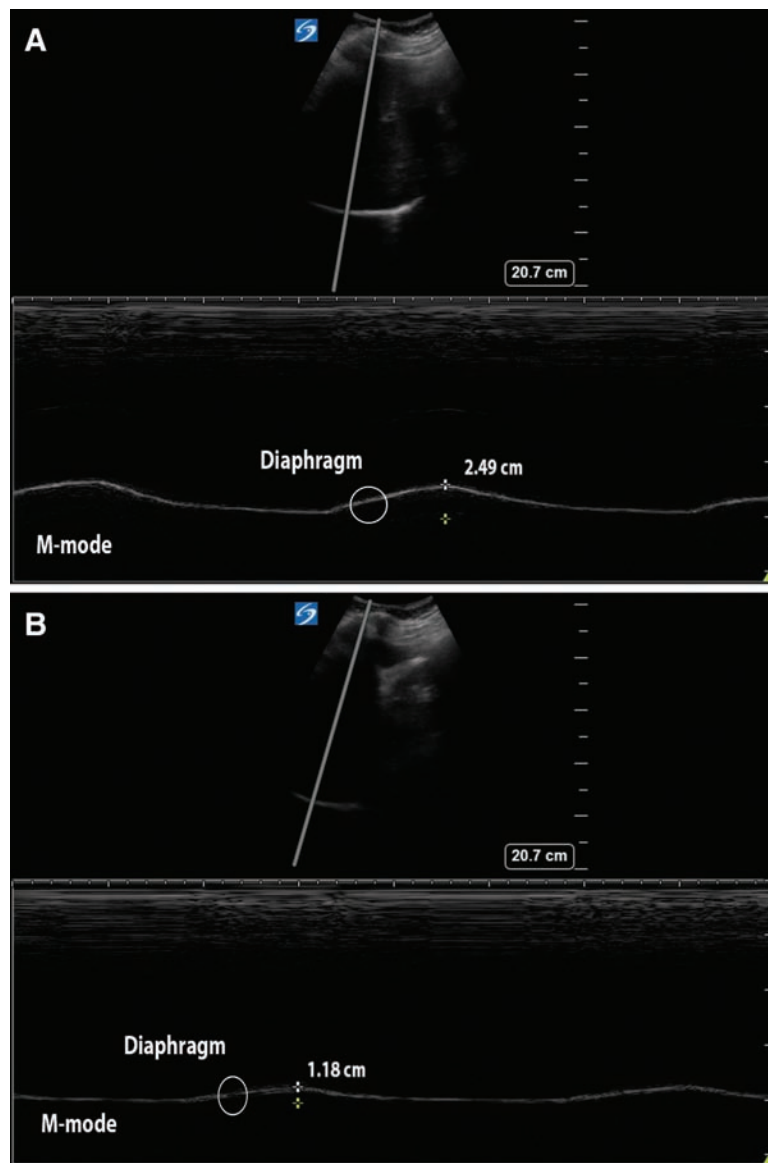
Curvilinear transducer ultrasound image of the right diaphragm using the liver as an acoustic window in two-dimensional B-mode and M-mode. (A) Preblock (baseline) diaphragmatic excursion was checked on deep breathing in M-mode (2.49 cm). (B) Postblock assessment of diaphragmatic excursion. Reduced diaphragmatic excursion was seen in M-mode (1.18 cm); the decrease in diaphragmatic excursion was 52.6%, indicating partial hemidiaphragmatic paresis.
